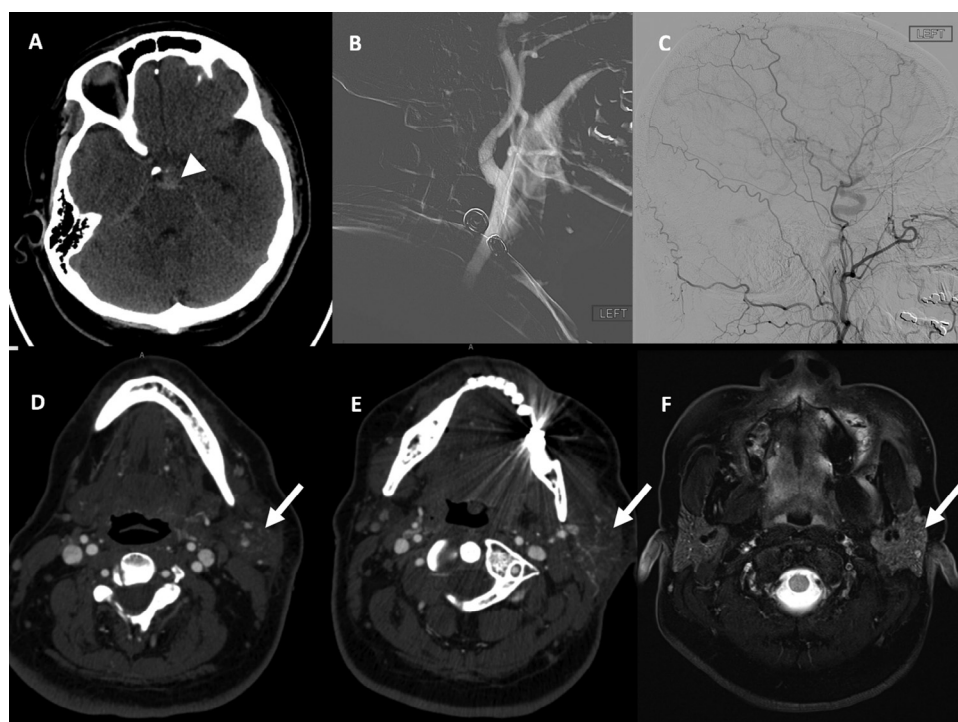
(A) Noncontrast computed tomography (CT) scan indicating the subarachnoid hemorrhage (arrowhead); (B) lateral left common carotid artery roadmap angiogram revealing normal carotid bifurcation; (C) lateral left external carotid artery angiogram indicating normal anatomy; (D–F) axial CT with contrast revealing an enlarged and hypervascular left parotid artery (arrow) with normal right parotid anatomy.
